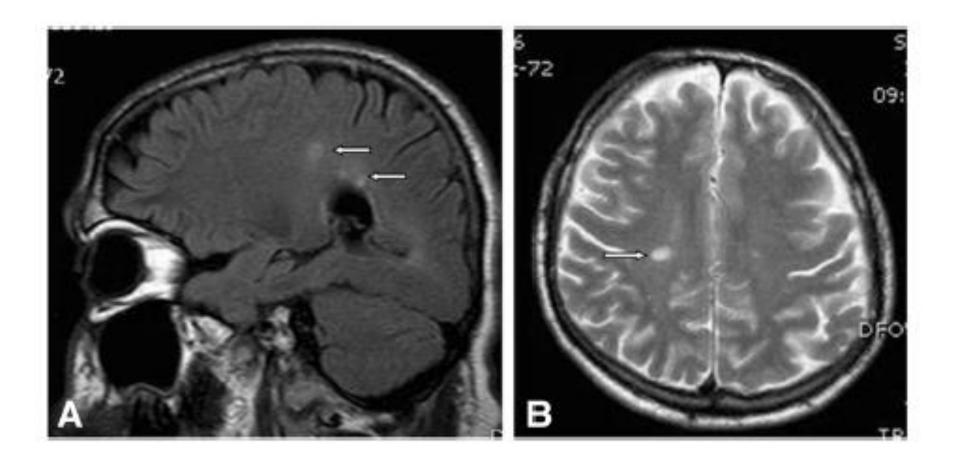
Sagittal fluid attenuated inversion recovery (FLAIR) (A) and axial T2-weighted (B) scans demonstrating ovoid hyperintense lesions in the deep periventricular white matter (arrows).
